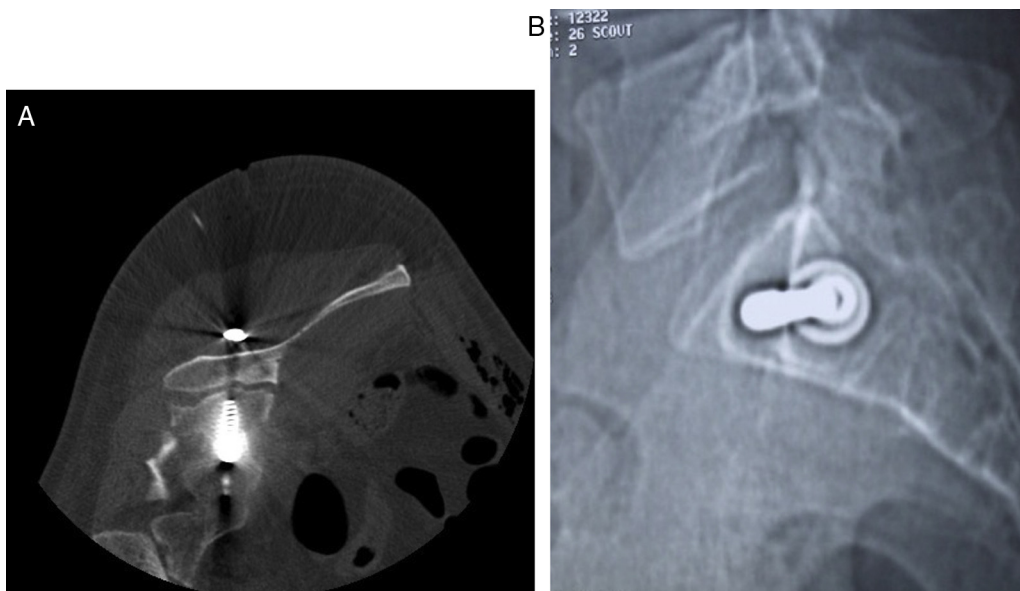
Final position of screw confirmed in axial and sagittal CT sections.
